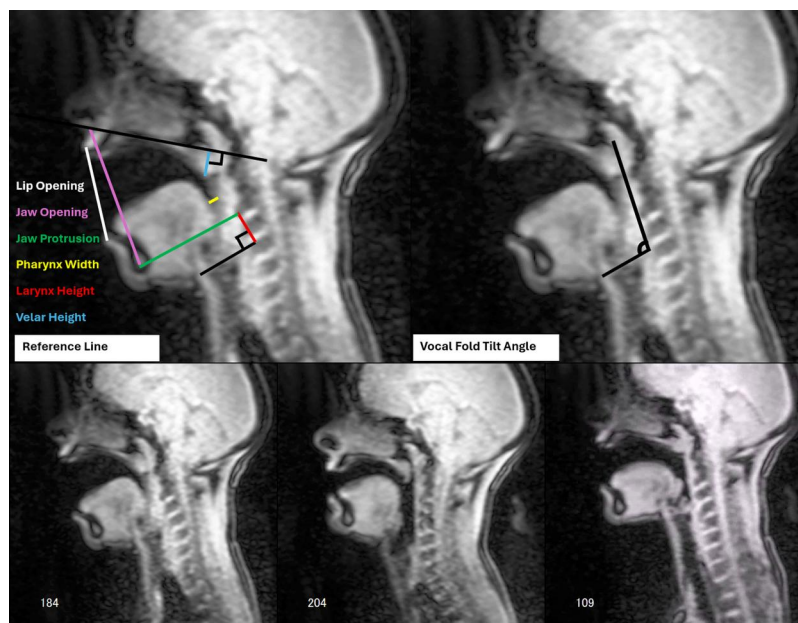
MRI images representing linear 2D measurements (top left), angular measurement (top right), and the three voice qualities: scream S2 (bottom left), sob (bottom middle), and belt (bottom right).
